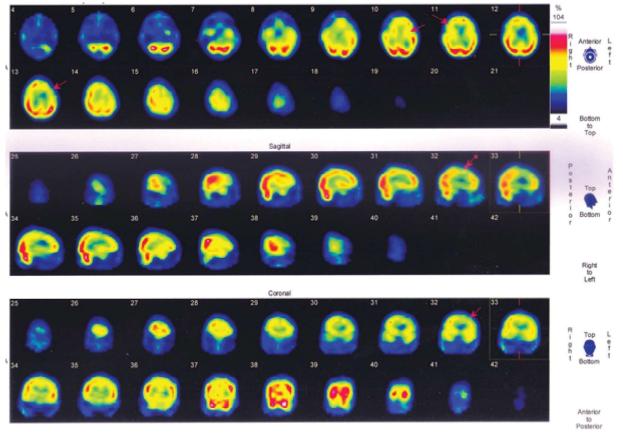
SPECT showinghypoperfusion of fronto-parietal regeion of both cortex(Right>Left) and basal ganlia(Left)
